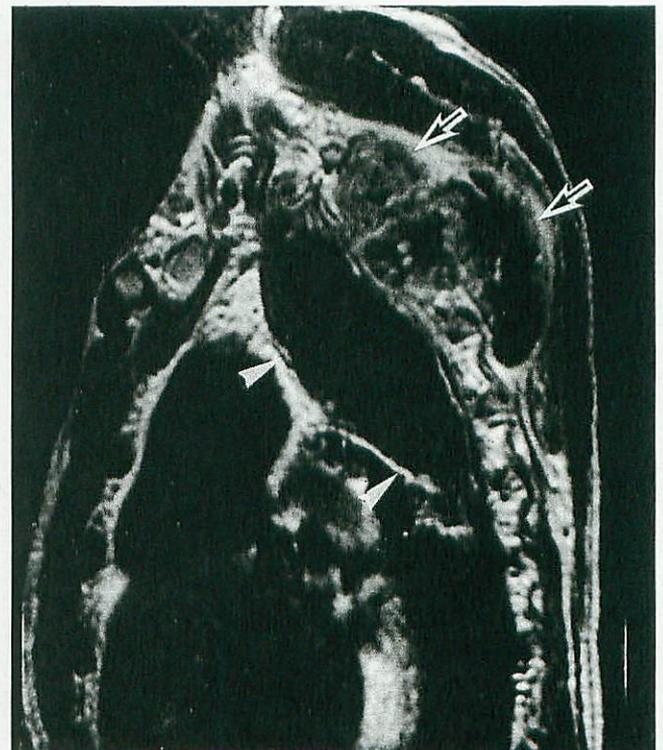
Postcontrast magnetic resonance image (T1-weighted sagittal imaging) showing a large tumor (arrows) with an irregular non-contrast-enhanced area inside the lesion (non-Hodgkin's lymphoma, pyothorax-associated lymphoma, diffuse large cell, B cell or null type, 64-year-old man). The tumor proliferated adjacent to the cyst-like wall of chronic pyothorax (arrowheads), posteriorly invaded into the back muscle.
